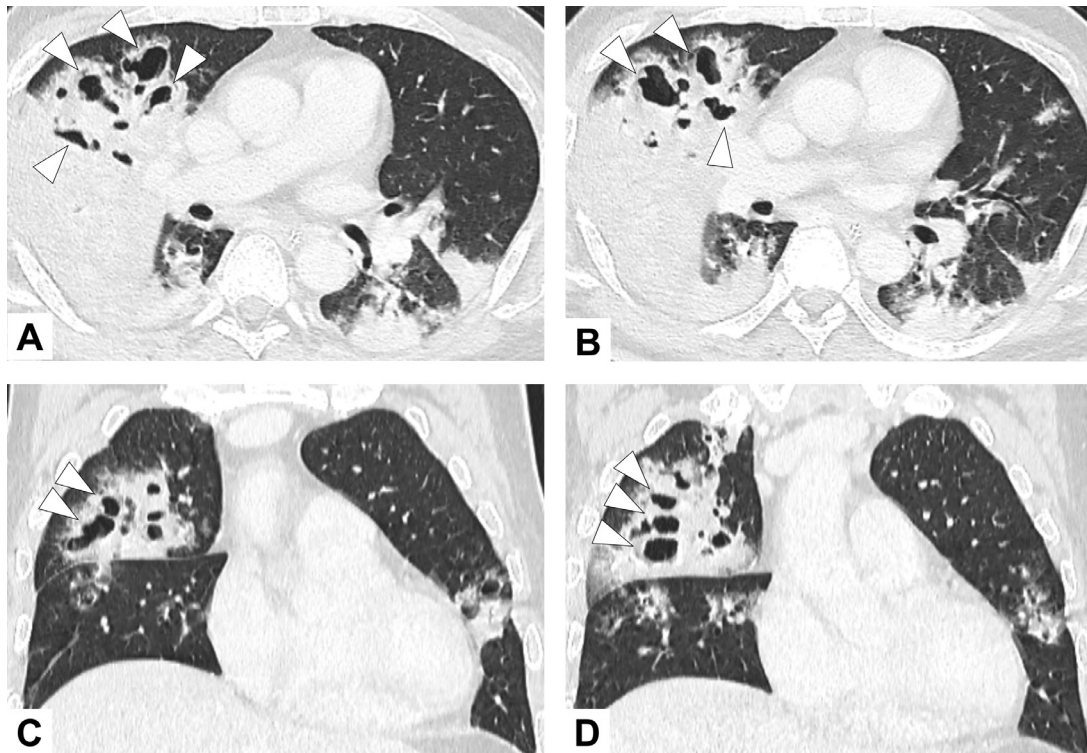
Axial (A, B) and coronal-reformatted (C, D) chest CT on hospital day 14. Chest CT shows that multiple bronchiectatic cavity formations have expanded and increased (arrowhead) and bilateral consolidations have exacerbated.
